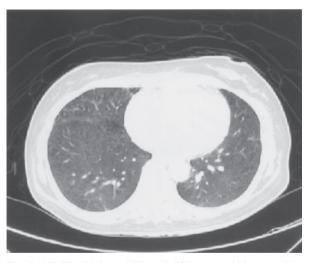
HRCT still showed bilateral diffuse ground-glass opacities after 4 weeks, but improved as compared with the previous film.
